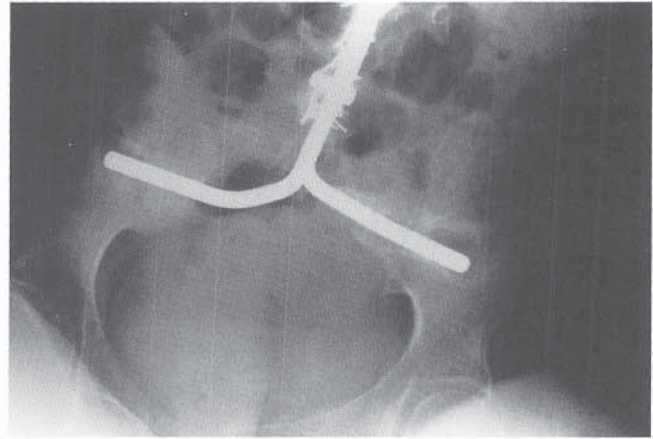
AP pelvic radiograph of a patient who underwent posterior spinal fusion for scoliosis secondary to cerebral palsy using the Luque-Galveston technique. There is radiolucency present around the iliac portion of each rod, indicating loosening. The patient was asymptomatic.
